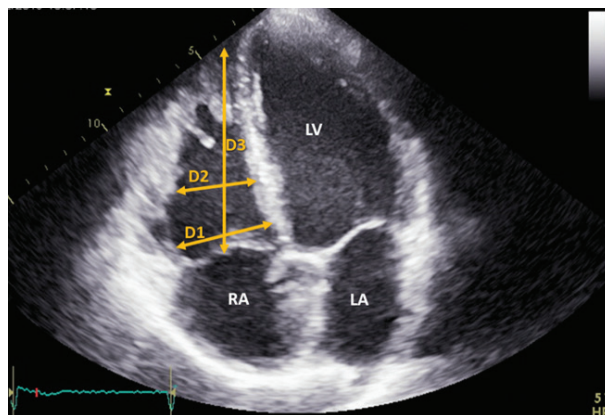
Apical 4-chamber view focused on the right ventricle. Example of measurement of basal (D1) and mid-cavity (D2) transverse dimensions, as well as a linear dimension (D3). The measurements of D2 in end-systole and end-diastole were used for the calculation of the right ventricular shortening fraction = (D2 diast – D2 syst) / D2 diast
